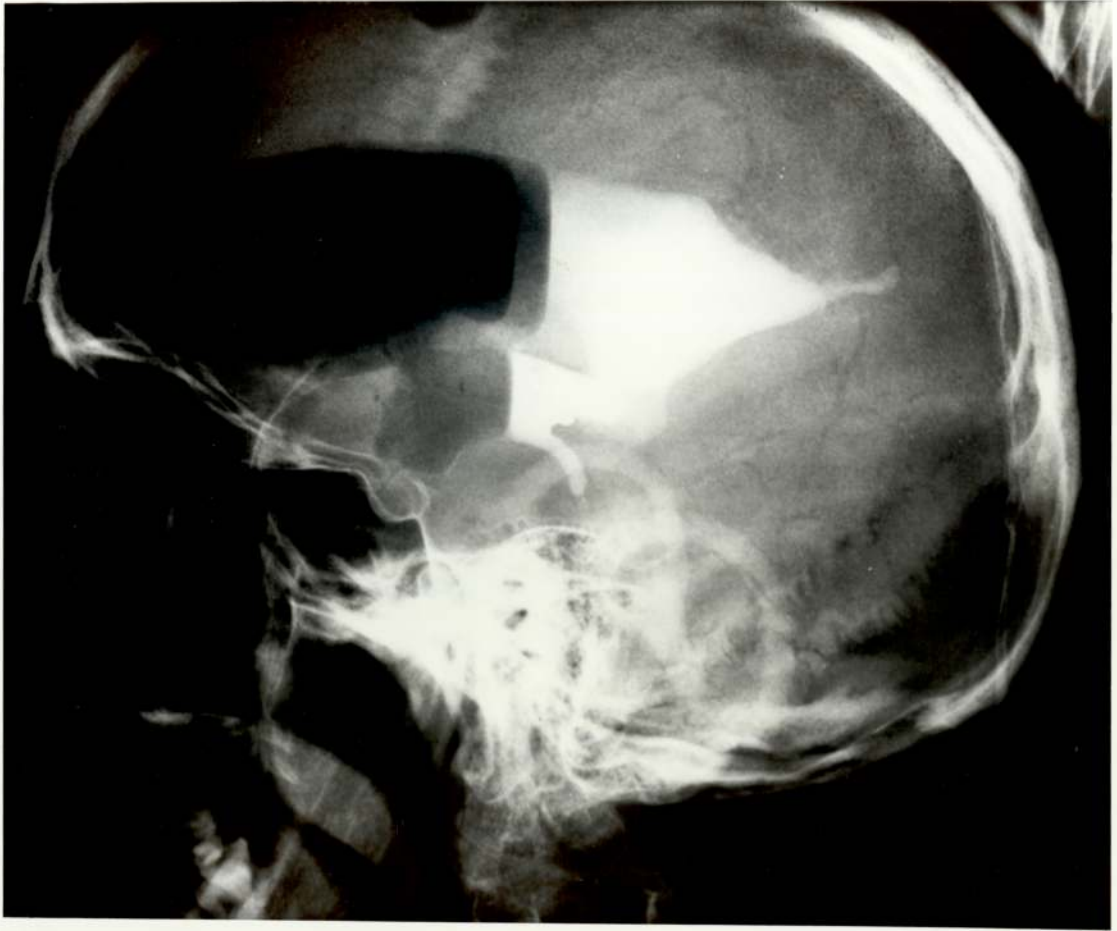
A Dandy-Walker cyst. X-ray ventriculogram
